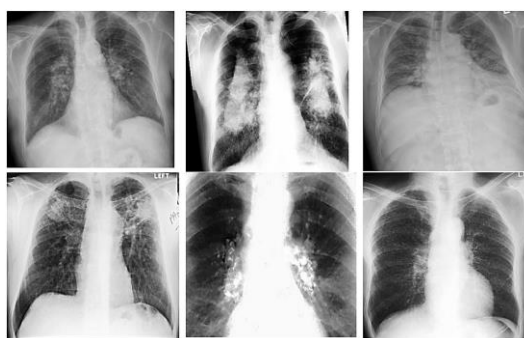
Silicosis Chest X-ray images of complicated with progressive massive fibrosis (Source: Radiopaedia.org)
